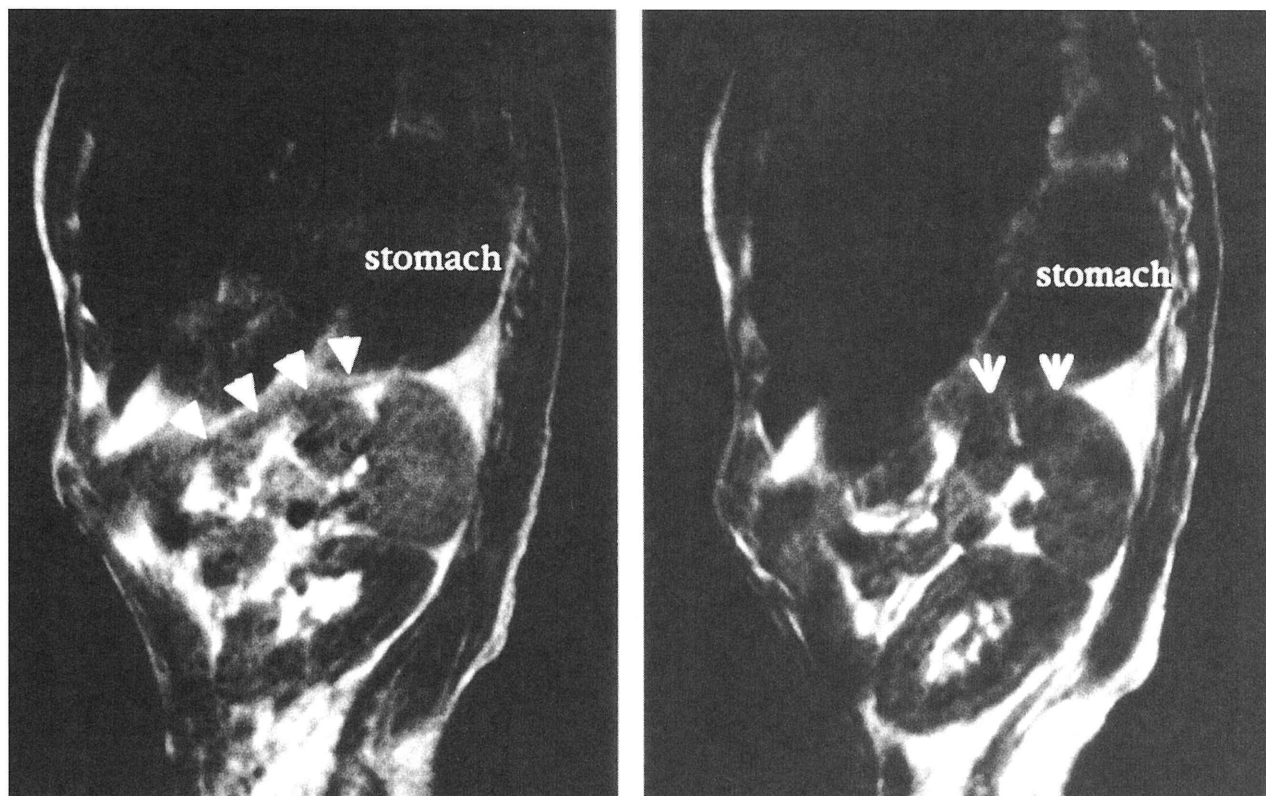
Chest-abdominal MRI: On low intensity MRI on T1 enhanced sagittal section (▼), the stomach is above the diaphragm and an 8 cm diaphragm defect is observed (↓).
